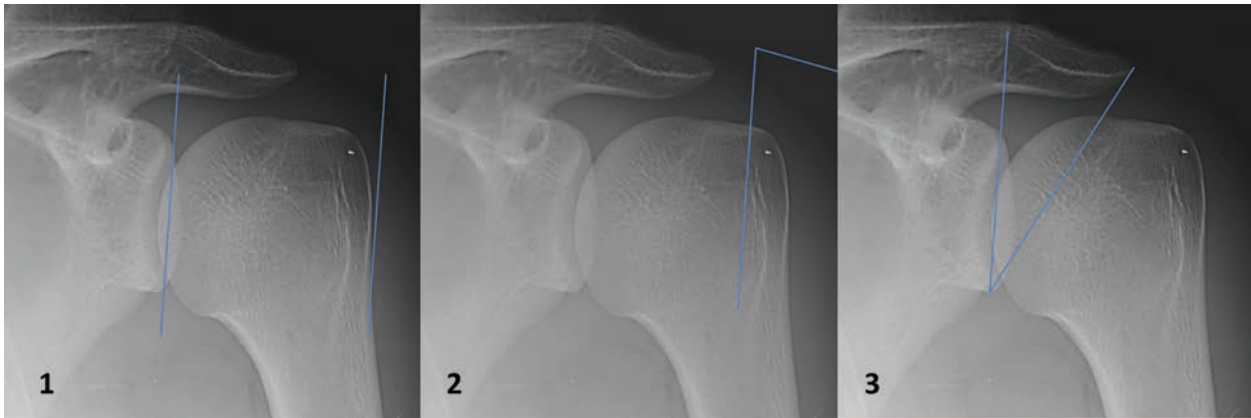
Radiograph measurements.¹⁷ 1. The acromion index is the ratio between the distance from the glenoid plane to the acromion and the distance from the glenoid plane to the lateral aspect of the humeral head. This should be > 0.68 . 2. The lateral acromion angle is the angle between a line drawn parallel to the sclerotic line of the acromion undersurface and a line between the superior and inferior glenoid fossa. This should be < 83 degrees. 3. The critical shoulder angle (CSA) is the angle between the first line connecting the inferolateral point of the acromion and a second line connecting the inferior border of the glenoid to the most inferolateral point of the acromion. This should be > 35 degrees. CSA reflects the lateral extension of the acromion and the glenoid inclination with only one radiologic parameter and has been found to be the most powerful predictor for rotator cuff disease.
